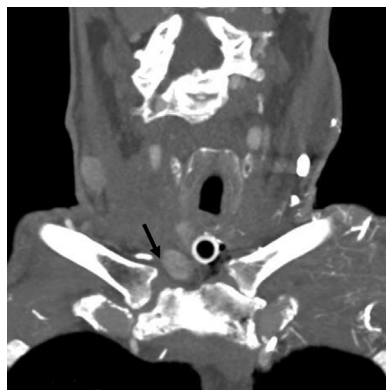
Computed tomography angiogram coronal view. Arrow points to a vascular lesion arising from the right common carotid artery, a probable pseudoaneurysm.
